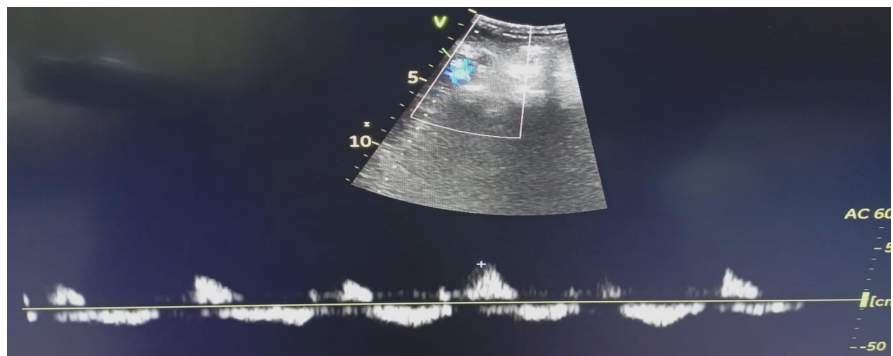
PW Doppler assessment of CFV waves in short axis view showing a severely congested vein with bidirectional pattern with flow reversal more than one-third the antegrade flow (CFW = common femoral vein).
